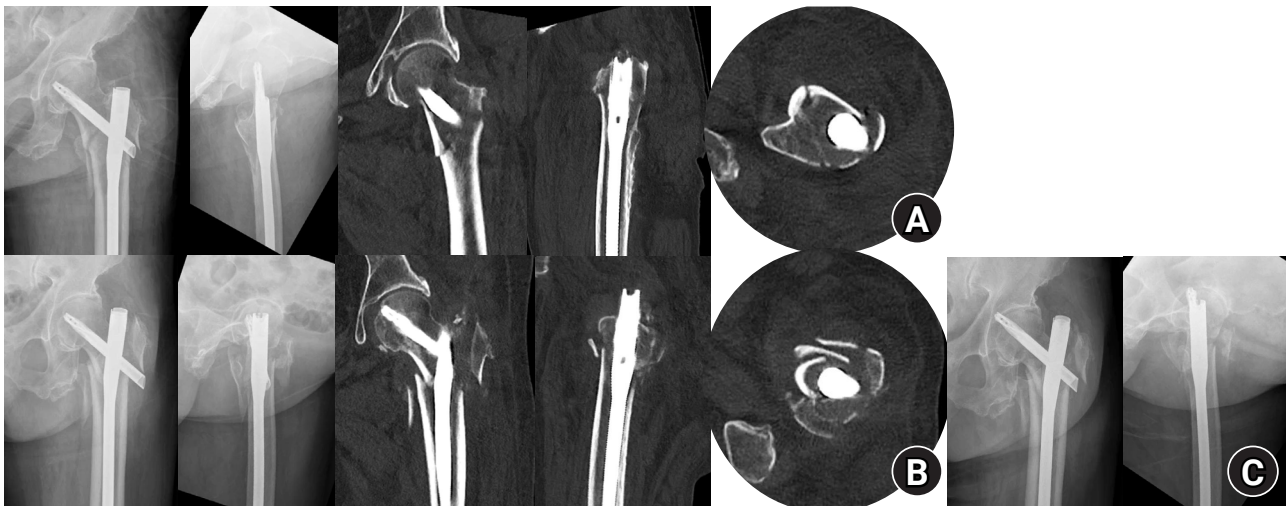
Radiographic images of an 82-year-old female patient with an AO/OTA A3 intertrochanteric femur fracture treated with the percutaneous anterior leverage technique. (A) Postoperative radiographs showing positive medial cortical support and neutral anterior cortical support. (B) Radiographs obtained 3 weeks postoperatively at the first outpatient visit, showing progression to negative anteromedial cortical support with cortical breakage. (C) Radiographs obtained 7 weeks postoperatively, demonstrating blade cut-through.
